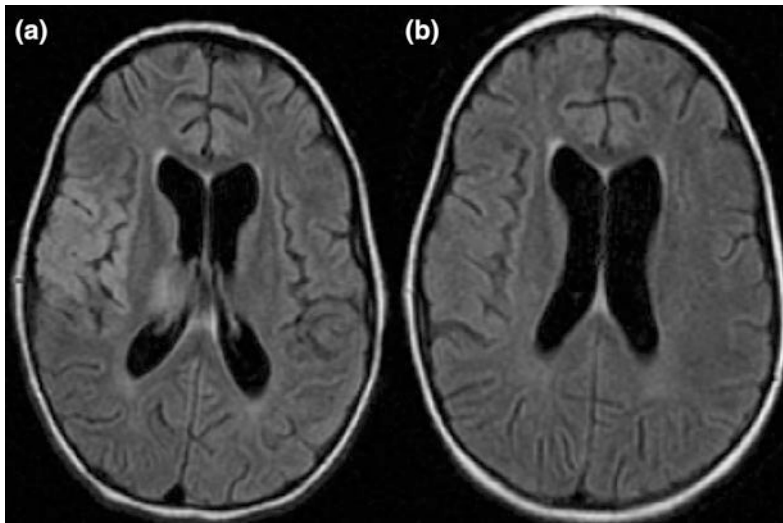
Increased T2 signal (FLAIR protocol) in epilepsy partialis continua arising from the right hemisphere (a), with resolution after i.v. anesthesia (b)
